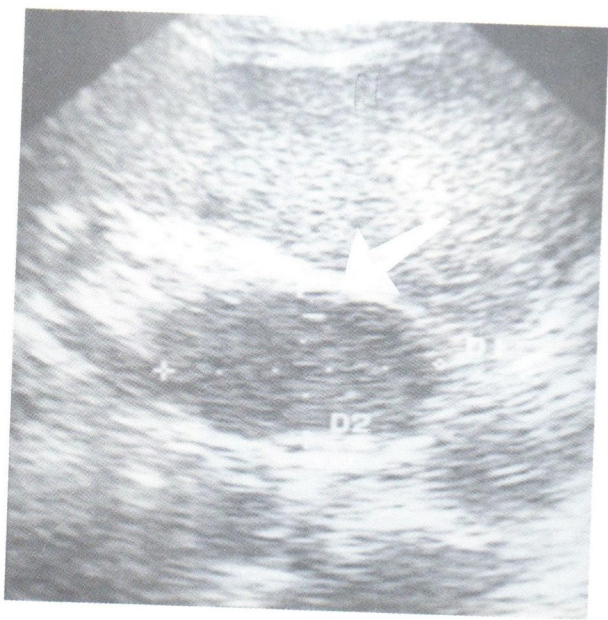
Ultrasonography of the upper abdomen revealed an oval shape homogeneously low echoic mass, size 5.6 x 2.3 cm replacing right adrenal gland and 5 x 2.8 cm, replacing left adrenal gland. The masses had a well defined border.
